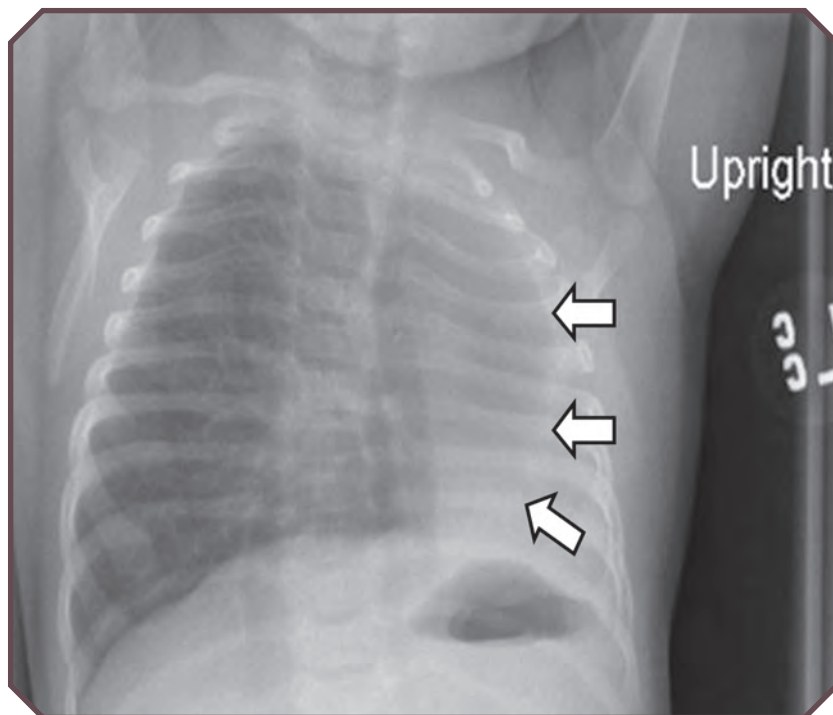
Frontal chest radiograph of a 1-month-old female infant with left pulmonary agenesis. Note the displacement of the heart and mediastinum into the left axillary line and herniation of the right lung into the left chest cavity (arrows).
